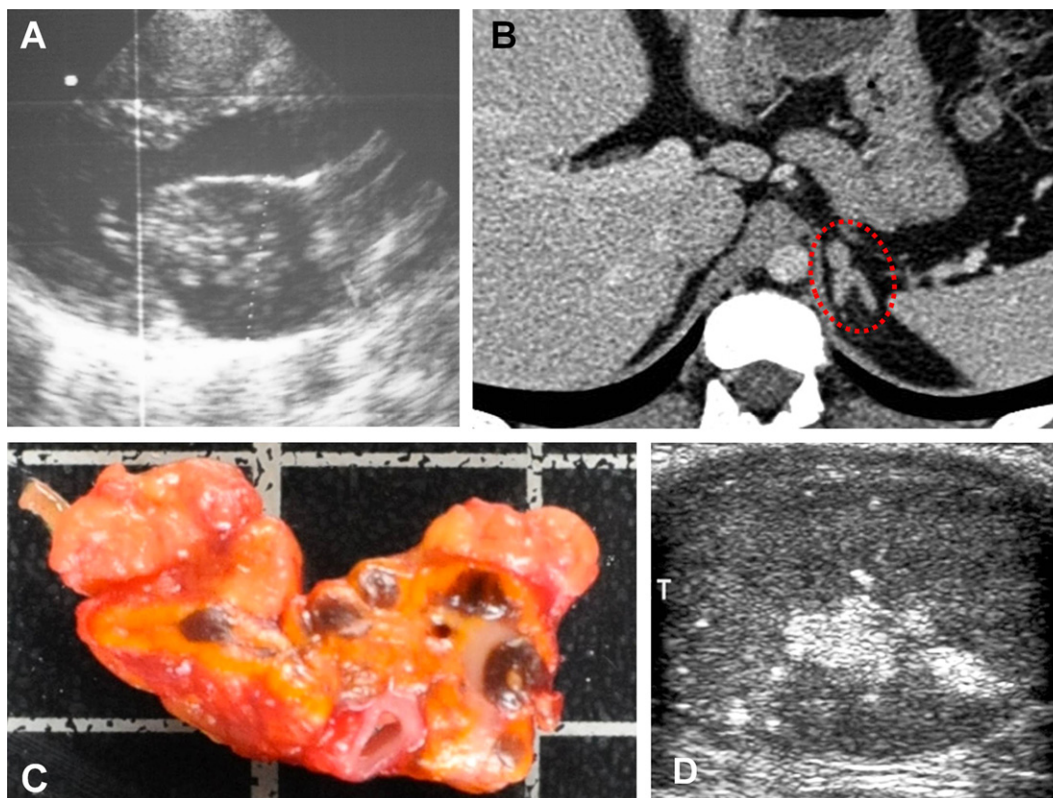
Radiological and pathological findings in CNC. (A) Typical presentation of a left atrial cardiac myxoma on transthoracic echocardiography. (B) PPNAD appearance on CT-scan: left adrenal hyperplasia with micronodules of the body of the adrenal (*red circle*). (C) Macroscopic presentation of PPNAD: normal size adrenal with multiple pigmented nodules. (D) Multiple microcalcifications typical of LCCST on testicular US.
